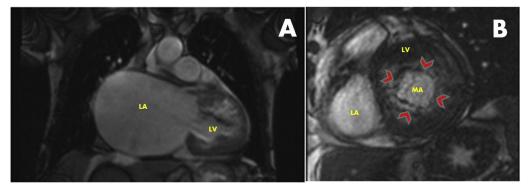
Cardiac magnetic resonance imaging, in steady-state free-precession, two-chamber view (A), showing extreme dilatation of the left atrium (LA); and short-axis view (B), showing the quadrangular morphology of the MV annulus (MA; *red arrowhead*). LA, Left atrium; *LV*, left ventricle.
